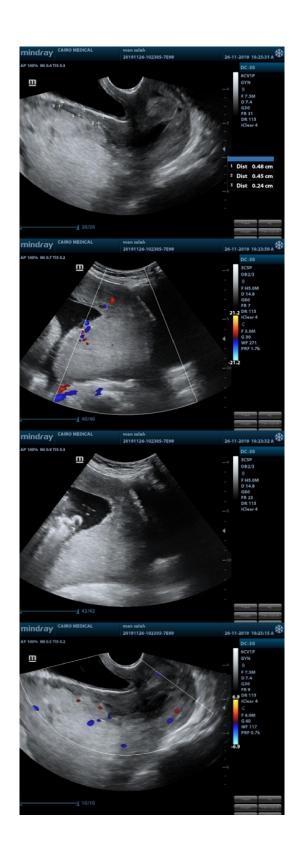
Ultrasound imaging of case 8
